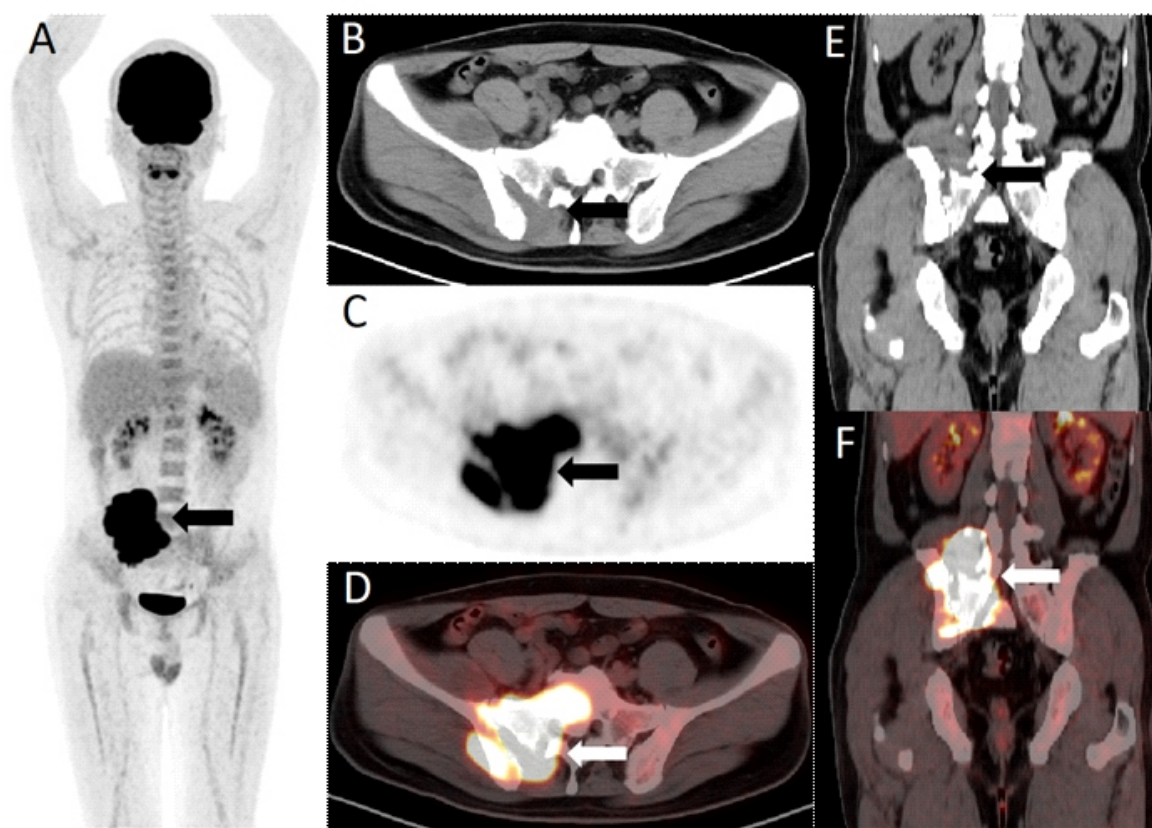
A 48-year-old man came to our hospital for the complaint of right lumbosacral pain for three months. The blood examination had no obvious abnormalities. Pelvic CT showed a mass in the sacroiliac joint with adjacent bone destruction. A malignancy was suspected. Thus, ¹⁸F-FDG PET/CT was performed for staging. Maximum intensity projection (MIP) image indicated an ¹⁸F-FDG-avid lesion in the sacroiliac joint area. The axial CT (B), PET (C), and fused images (D) and coronal CT (E), and fused images (F) showed a soft tissue mass with adjacent bone destruction in the sacroiliac joint, which had intense ¹⁸F-FDG uptake with a maximum standardized uptake value (SUVmax) of 29.77. Then, this patient underwent biopsy. The final pathology supported a diagnosis of NK/T cell lymphoma. NK/T cell lymphoma mainly occurs in nasal cavity and adjacent areas. Rare sites include vagina [1], vocal cord [2], skin [3], breast [4], adrenal [5]. However, NK/T cell lymphoma in the sacroiliac joint is very rare. Li et al. (2020) [6] and Xu et al. (2020) [7] reported a case of diffuse large B-cell lymphoma in the sacrum presenting as osteolytic bone destruction with intense ¹⁸F-FDG uptake. Similar image appearance should be differentiated from plasmacytoma [8], Kaposi form hemangioendothelioma [9], chordoma [10], giant cell tumor [11]. Our case added the knowledge of another rare site of NK/T cell lymphoma, which should be regarded as a differential diagnosis for sacroiliac joint mass with intense ¹⁸F-FDG uptake.
